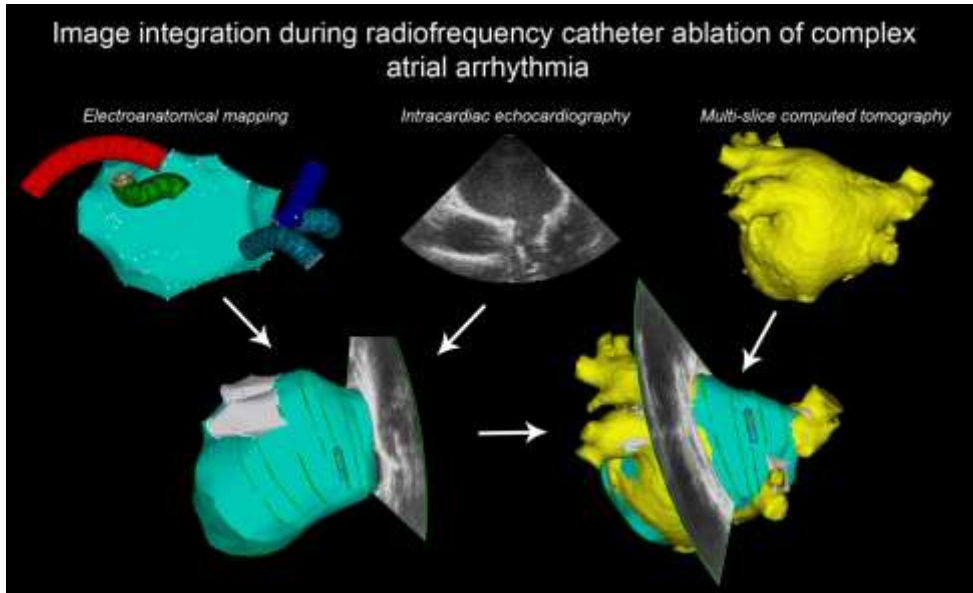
Example of integration of different imaging modalities to facilitate radiofrequency catheter ablation of complex atrial arrhythmia. The integration of electroanatomical mapping, intracardiac echocardiography and multi-slice computed tomography combines non-fluoroscopic navigation, real-time visualization of important cardiac structures and highly detailed three-dimensional anatomical information that can be used to guide the ablation procedure.
